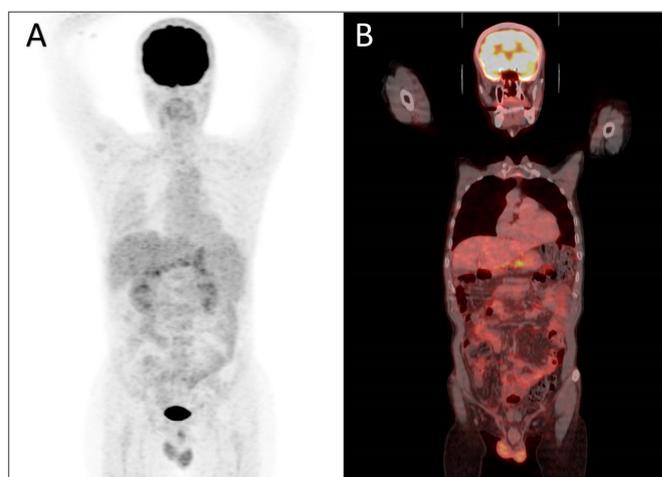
50 year old man with hepatocellular carcinoma who did not use iv PPI before imaging; FDG uptake in stomach was higher than liver (Visual score: Grade 3).
